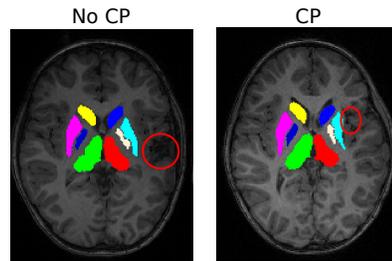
PC detection: Example of MRI of both classes. Left: injured brain without cerebral palsy. Right: injured brain of a child with cerebral palsy. Lesion is circled in red.
